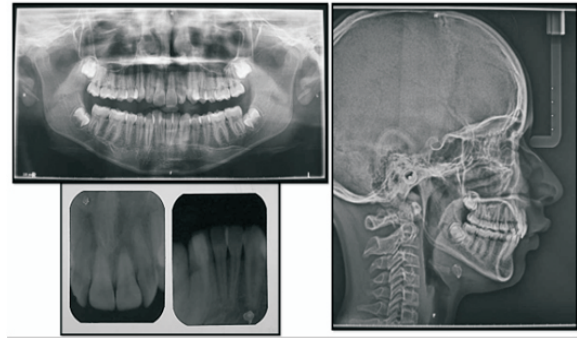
Pretreatment X-rays
